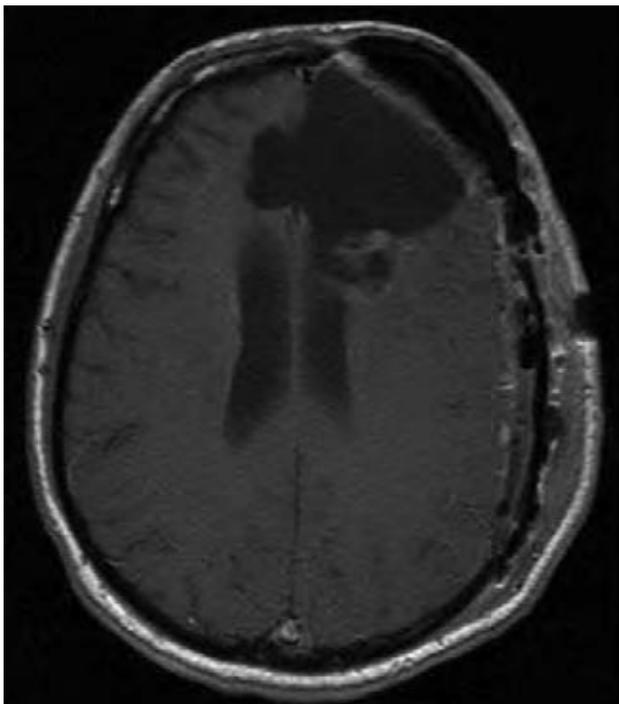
T1-weighted magnetic resonance imaging showed a recurrent tumor in the surgical site and a left hemispheric extra-axial mass with contrast enhancement (22).
